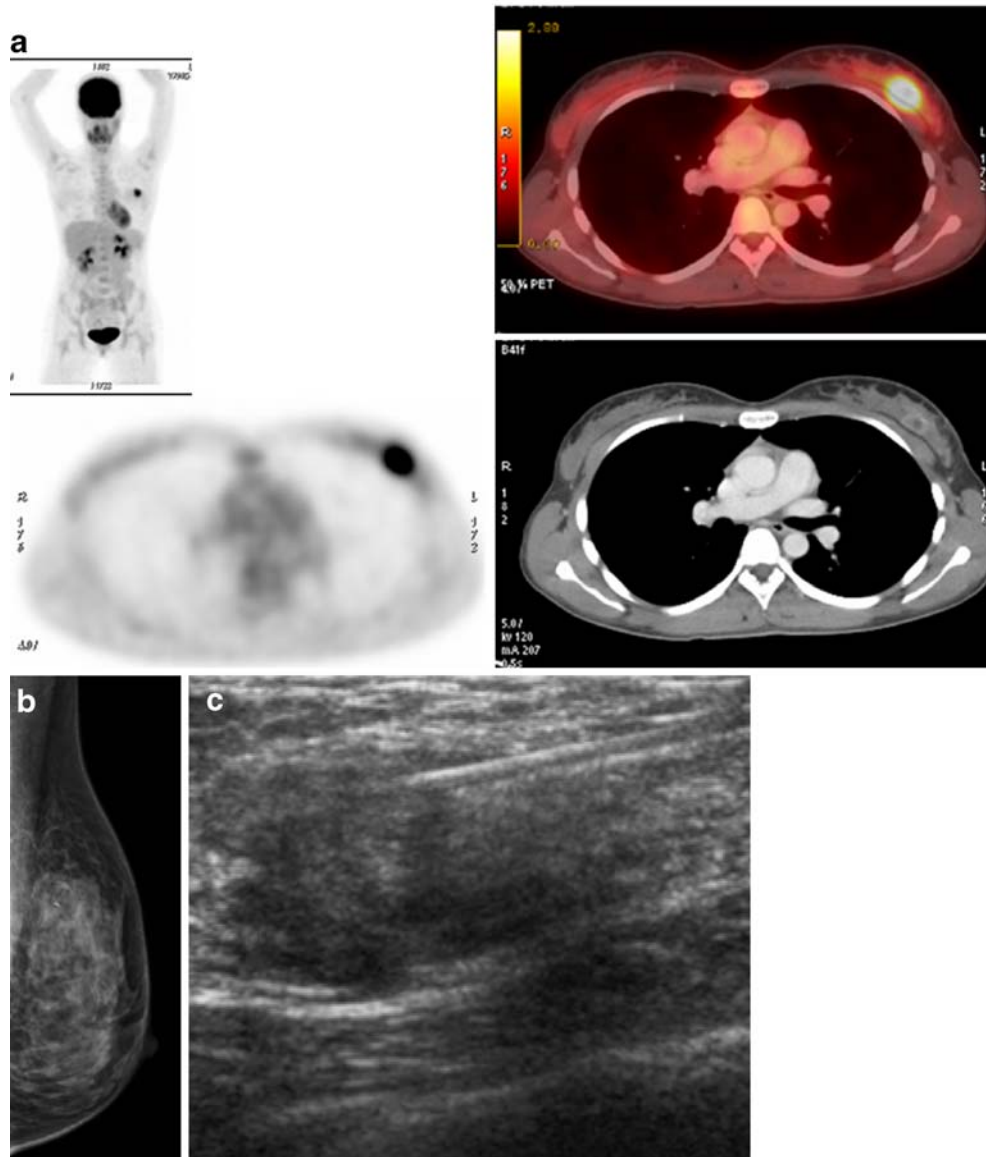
Biopsy-proven invasive ductal carcinoma, occult at mammography but seen at PET-CT and ultrasound. A. PET-CT images in axial and coronal projections demonstrate focus of increased uptake in left breast. B. Ultrasound shows an ill-defined hypoechoic mass. Ultrasound-guided core biopsy reveals invasive ductal carcinoma. C. Post-biopsy mammogram in lateral projection shows presence of the biopsy clip, but no mammographic sign of cancer is seen. This invasive ductal carcinoma is occult at mammography.
